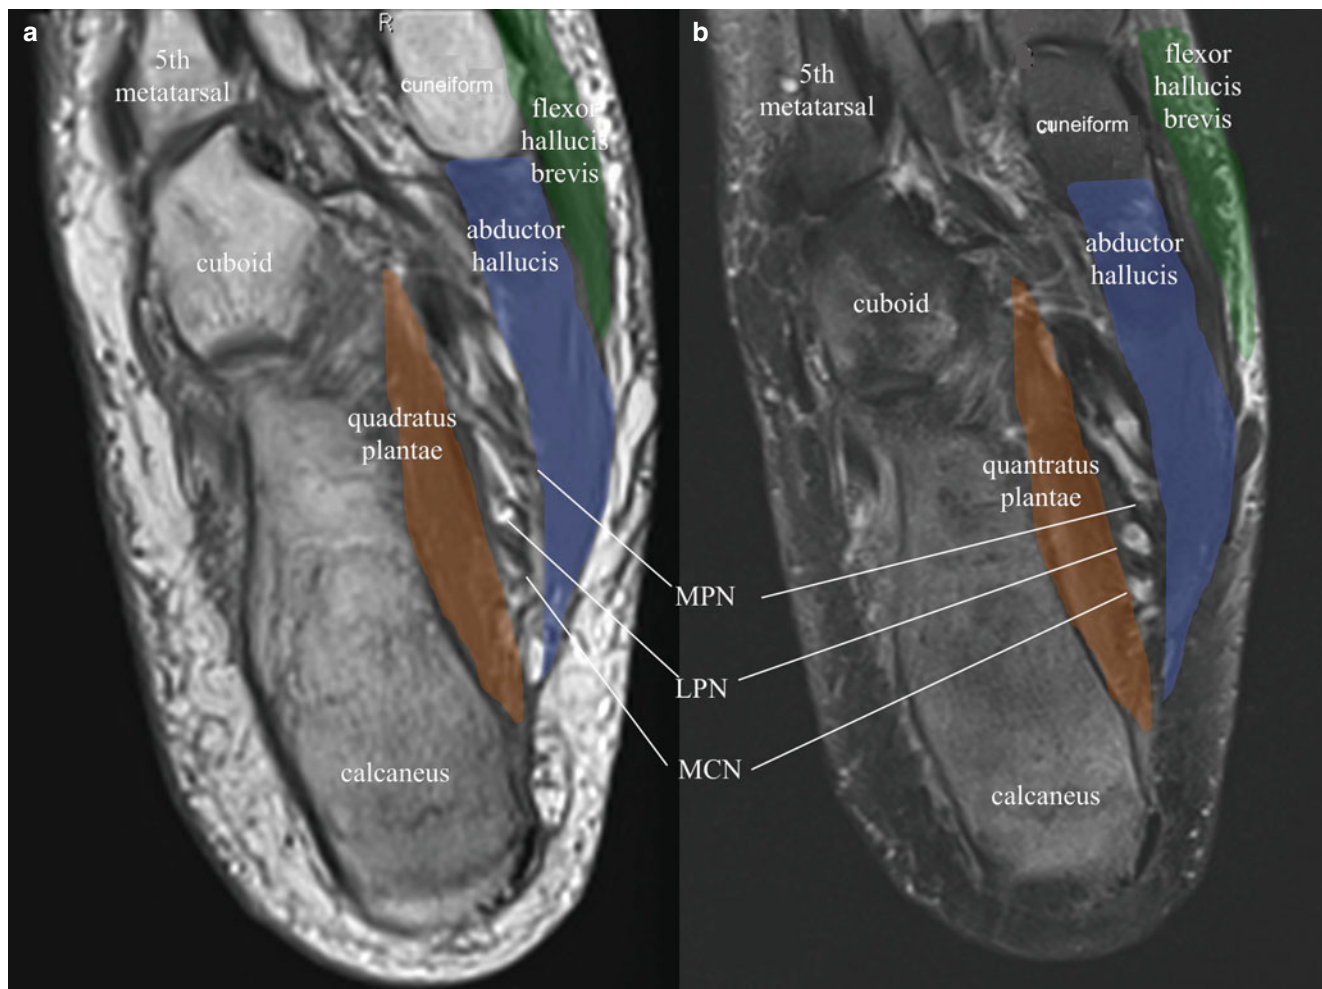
Axial MRI images; (a) T1-weighted image; (b) T2-weighted image; *MPN* medial plantar nerve, *LPN* lateral plantar nerve, *MCN* medial calcaneal nerve (Image courtesy of Andrea Trescot, MD)
